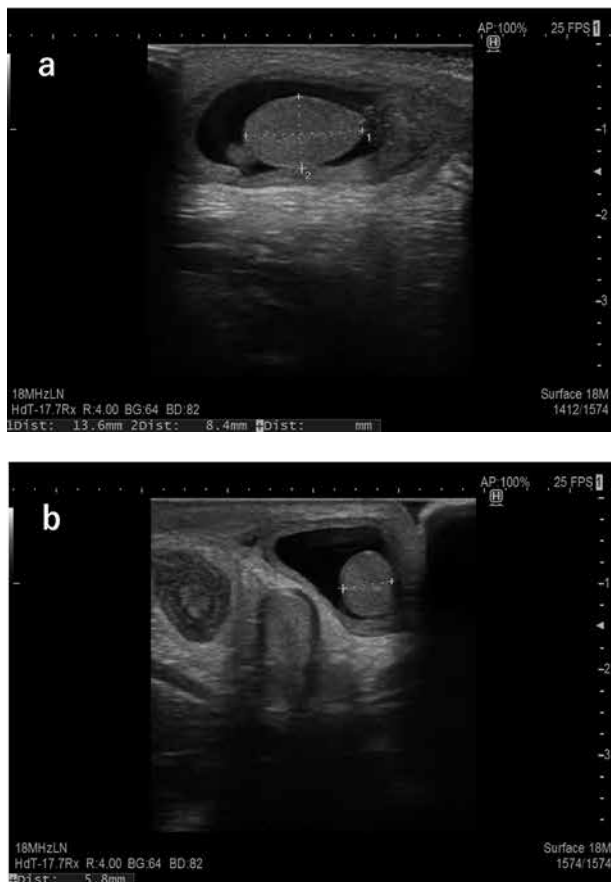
Ultrasonographic measurements of testicular size. a. Sagittal plane : Arrows indicate length (1) and width (2) of the testis. b. Transverse plane : Arrow indicates height of the testis.
